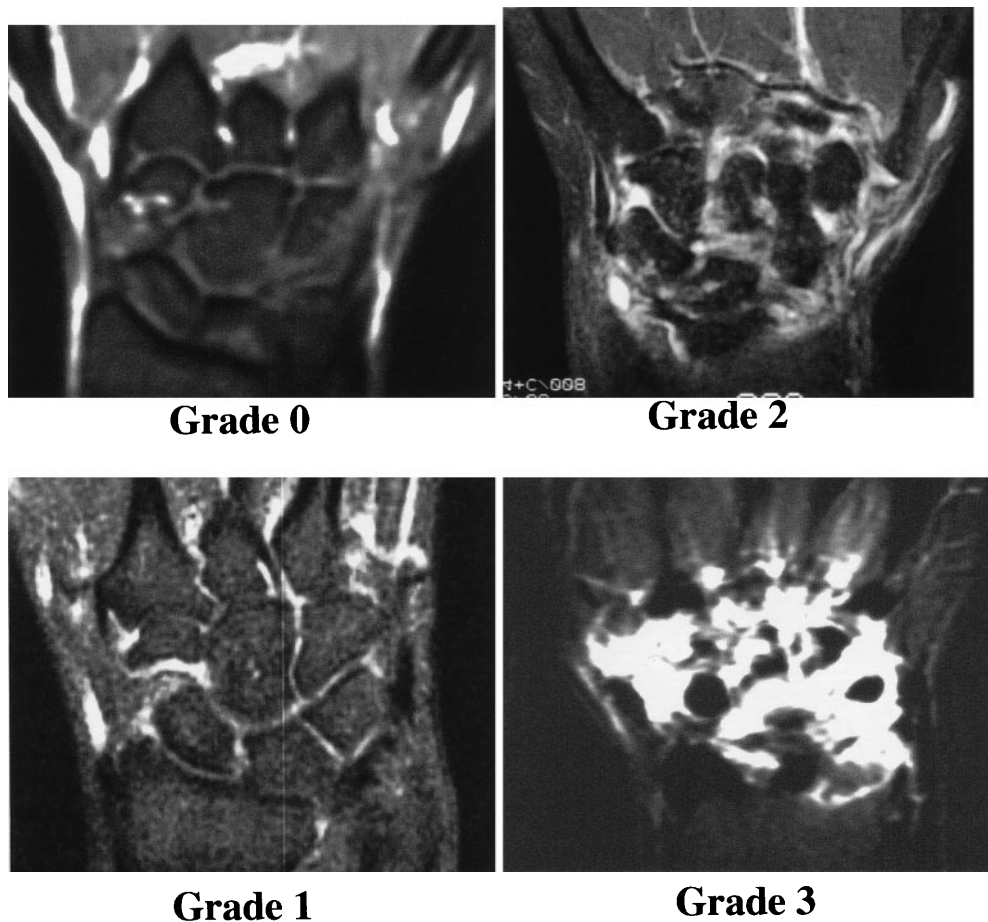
Grading of enhancement of the tendon sheath. T1-weighted spin-echo postcontrast magnetic resonance imaging (MRI) with fat suppression. Widths of tendons were measured. Grade 0, no visible enhancement; grade 1, slight enhancement (<2 mm); grade 2, moderate enhancement (width ≥ 2 mm, but <4 mm); grade 3, severe enhancement (width ≥ 4 mm)
